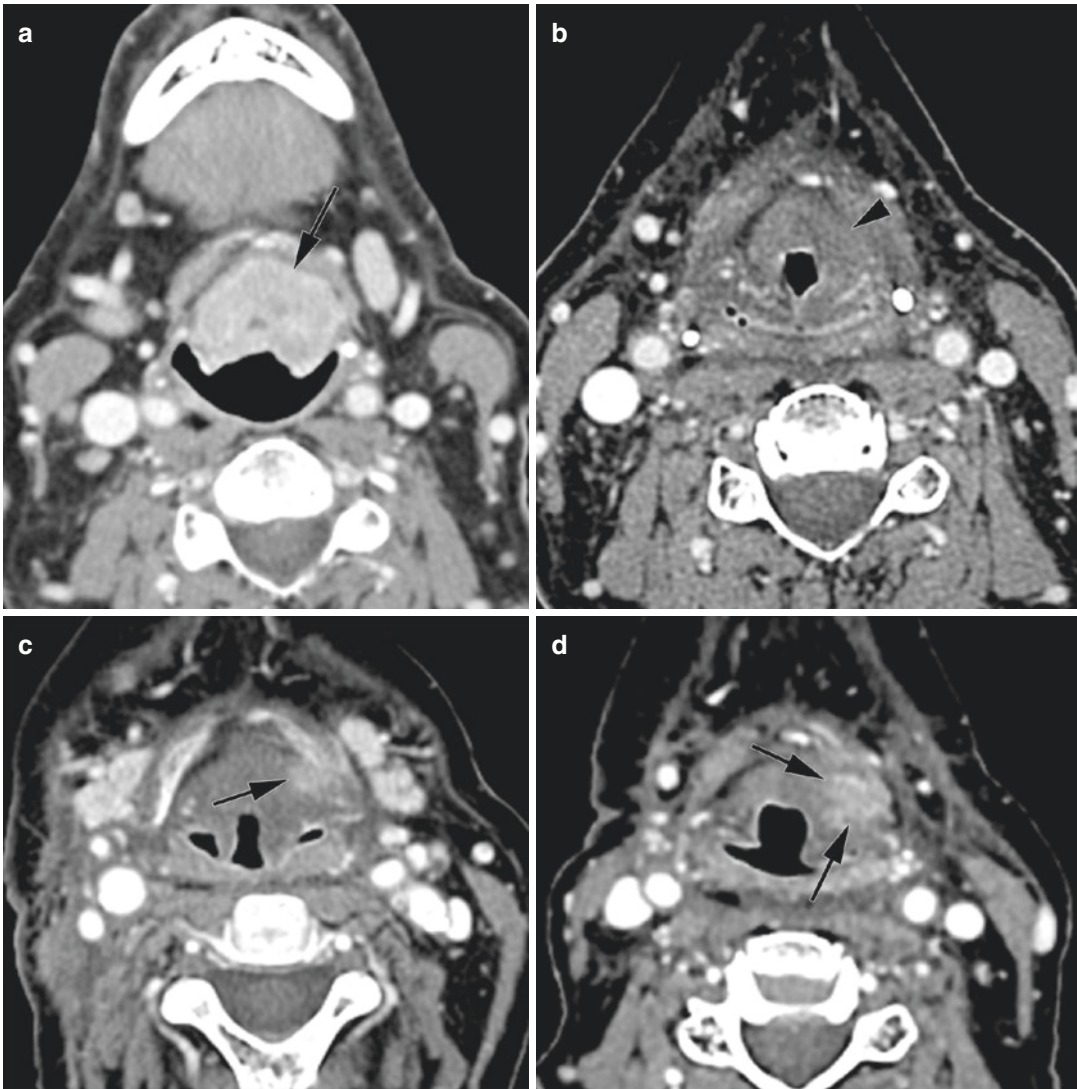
(a) Patient suffering from a large supraglottic cancer, invading the preepiglottic space (arrow), staged as a T3N2c cancer. It was decided to treat with concomitant chemoradiotherapy. (b) First follow-up CT, 4 months after treatment. The patient responded well to treatment, the tumor and adenopathies disappeared. Diffuse edema of the supraglottic larynx is seen, appearing slightly asymmetric (arrowhead). Therefore, further follow-up with intermittent CT scanning was recommended. (c) Follow-up CT study obtained 17 months after treatment shows appearance of a small contrast-enhancing lesion (arrowhead), close to the hyoid bone. This new finding is suspect for recurrent tumor. Clinical examination did not show any suspect finding, the patient was asymptomatic, and as the lesion was considered unreachable for biopsy, it was decided to adopt a wait-and-see policy. (d) Three months later, CT shows clear growth of the lesion
